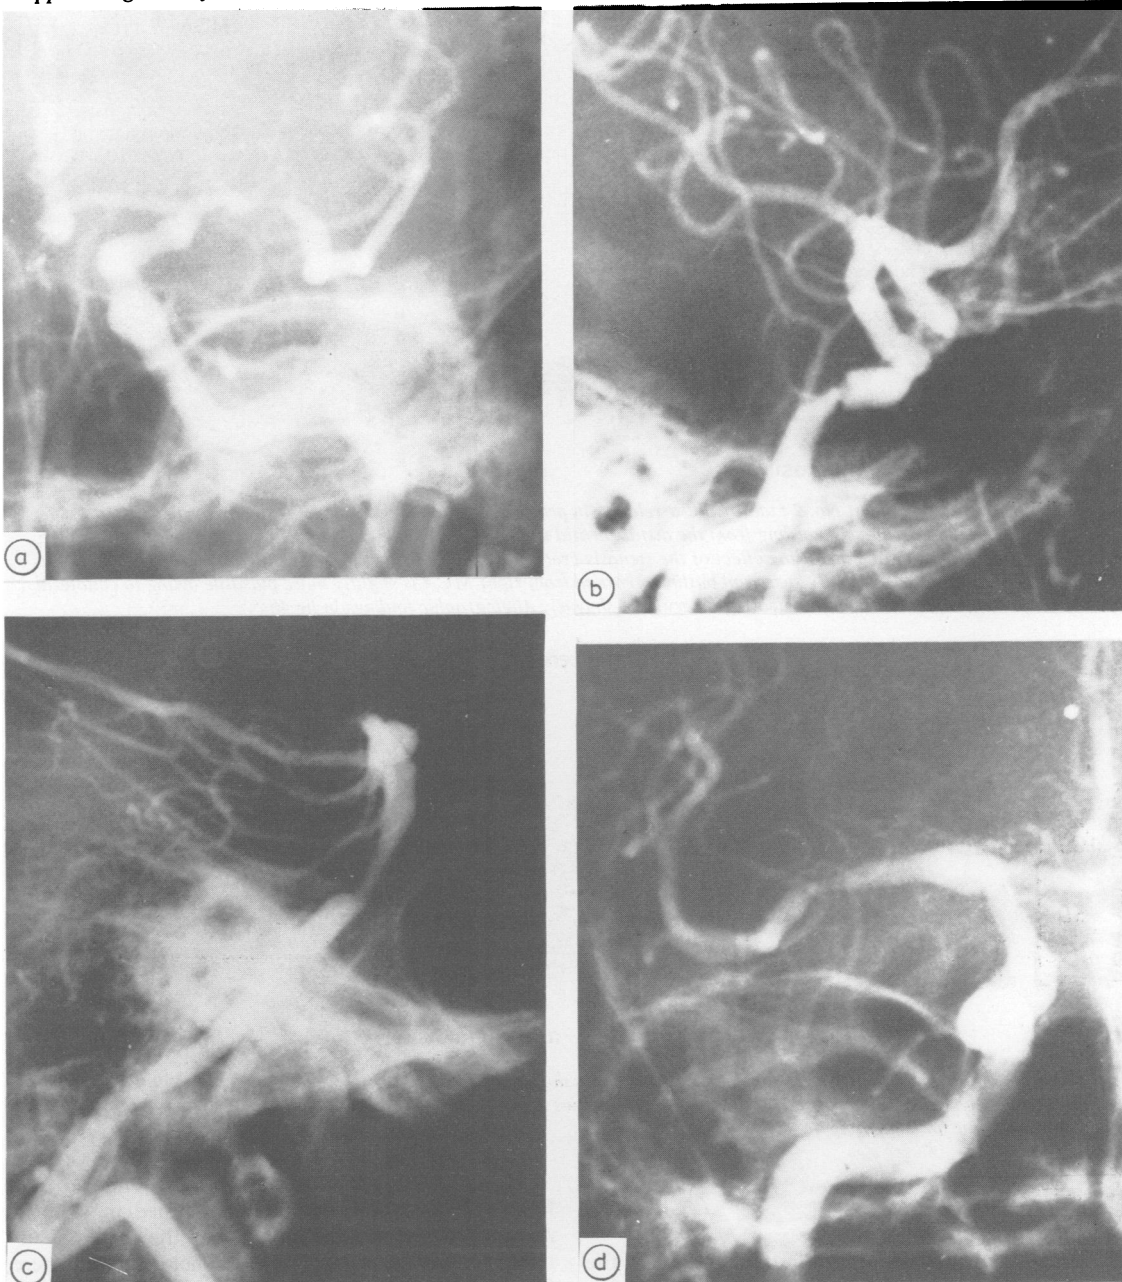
Angiographic findings in patient Nos. 1 to 4 (see table). Corresponding Doppler recordings are shown in fig 3 (No. 1), fig 5 (No. 2), fig 6 (No. 3) and fig 8 (No. 4).
